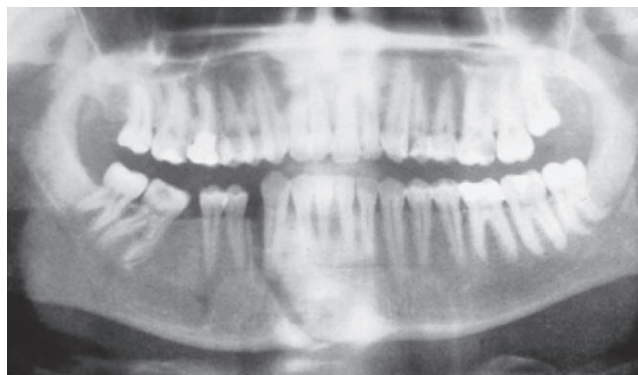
Panoramic radiograph of a mandibular jaw fracture.
